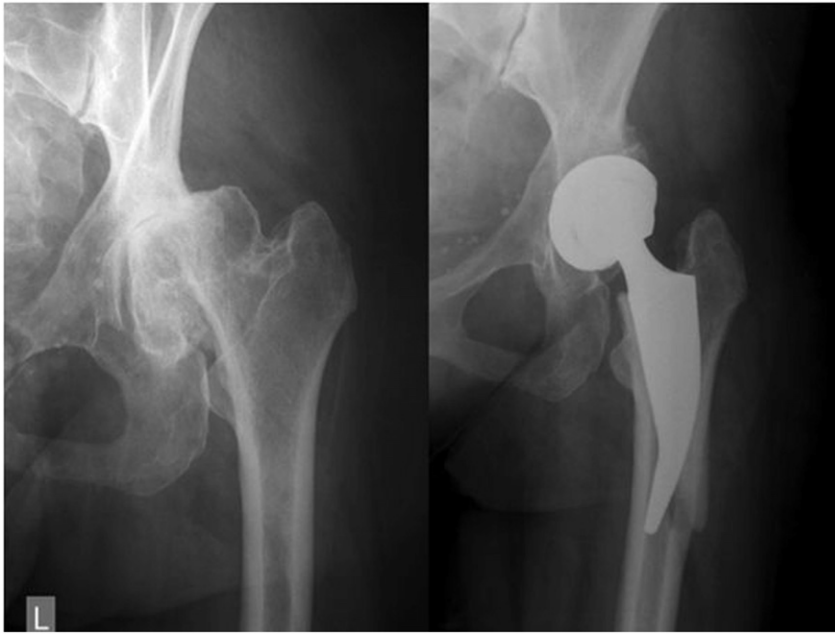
a: Preoperative radiograph showing left hip end stage osteoarthritis secondary to DDH of a 46 year old woman. b: Postoperative radiograph taken on day 2, showing a lateral flange fracture, but intact calcar, trochanters and distal diaphyseal bone.
